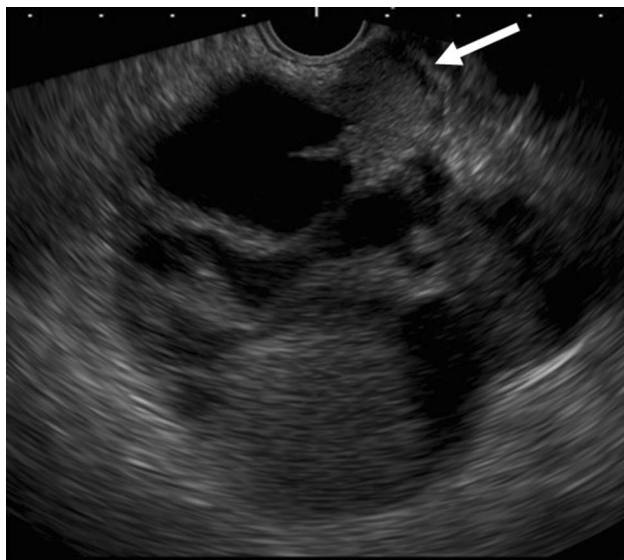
In endoscopic ultrasound, the mass was a thin-walled cyst with some solid masses and septum. For solid mass (arrow) of cystic lesion, endoscopic ultrasound-fine needle aspiration (EUS-FNA) was performed transgastrically with a 25-gauge Franseen needle
